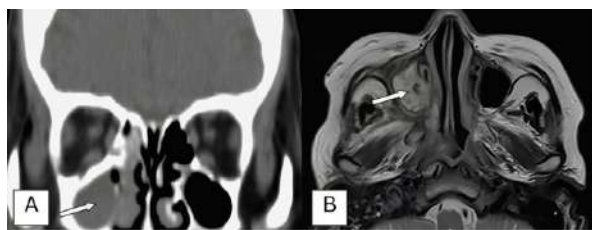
Early Radiologic Findings A. Plain Brain Coronal CT scan done 4 months prior to admission showing mucosal thickening in the right ethmoid and bilateral maxillary sinus. B. Plain Brain MRI T2 sequence, axial view done 1 month prior to admission, showing fluid signal in the right maxillary sinus.
